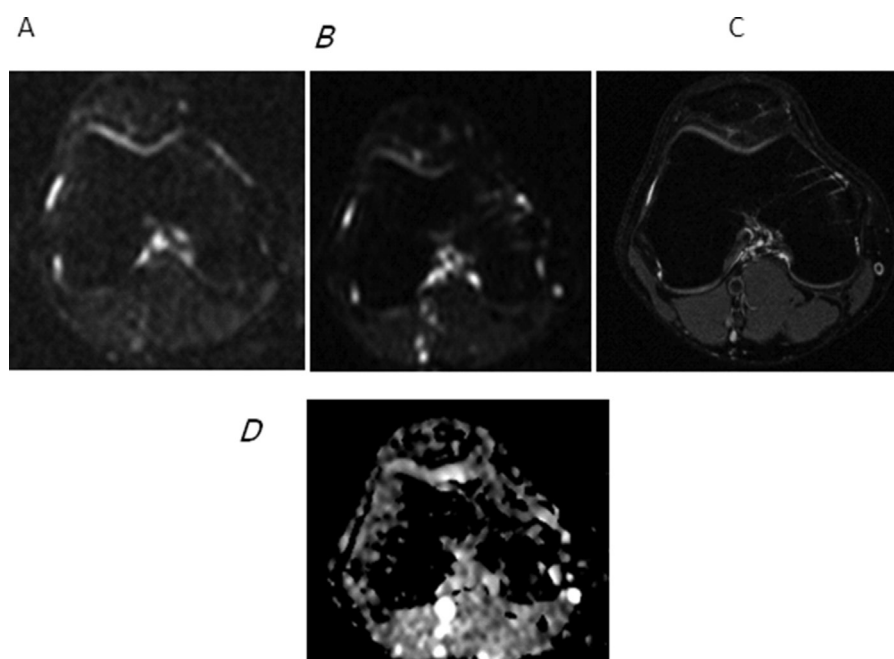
Visual presentation of the articular cartilage damage (chondromalacia) in DWI images with a b-value of 600 (A) and 0 (B). Visual presentation of a T₂ contrast image (C). ADC map (D).
